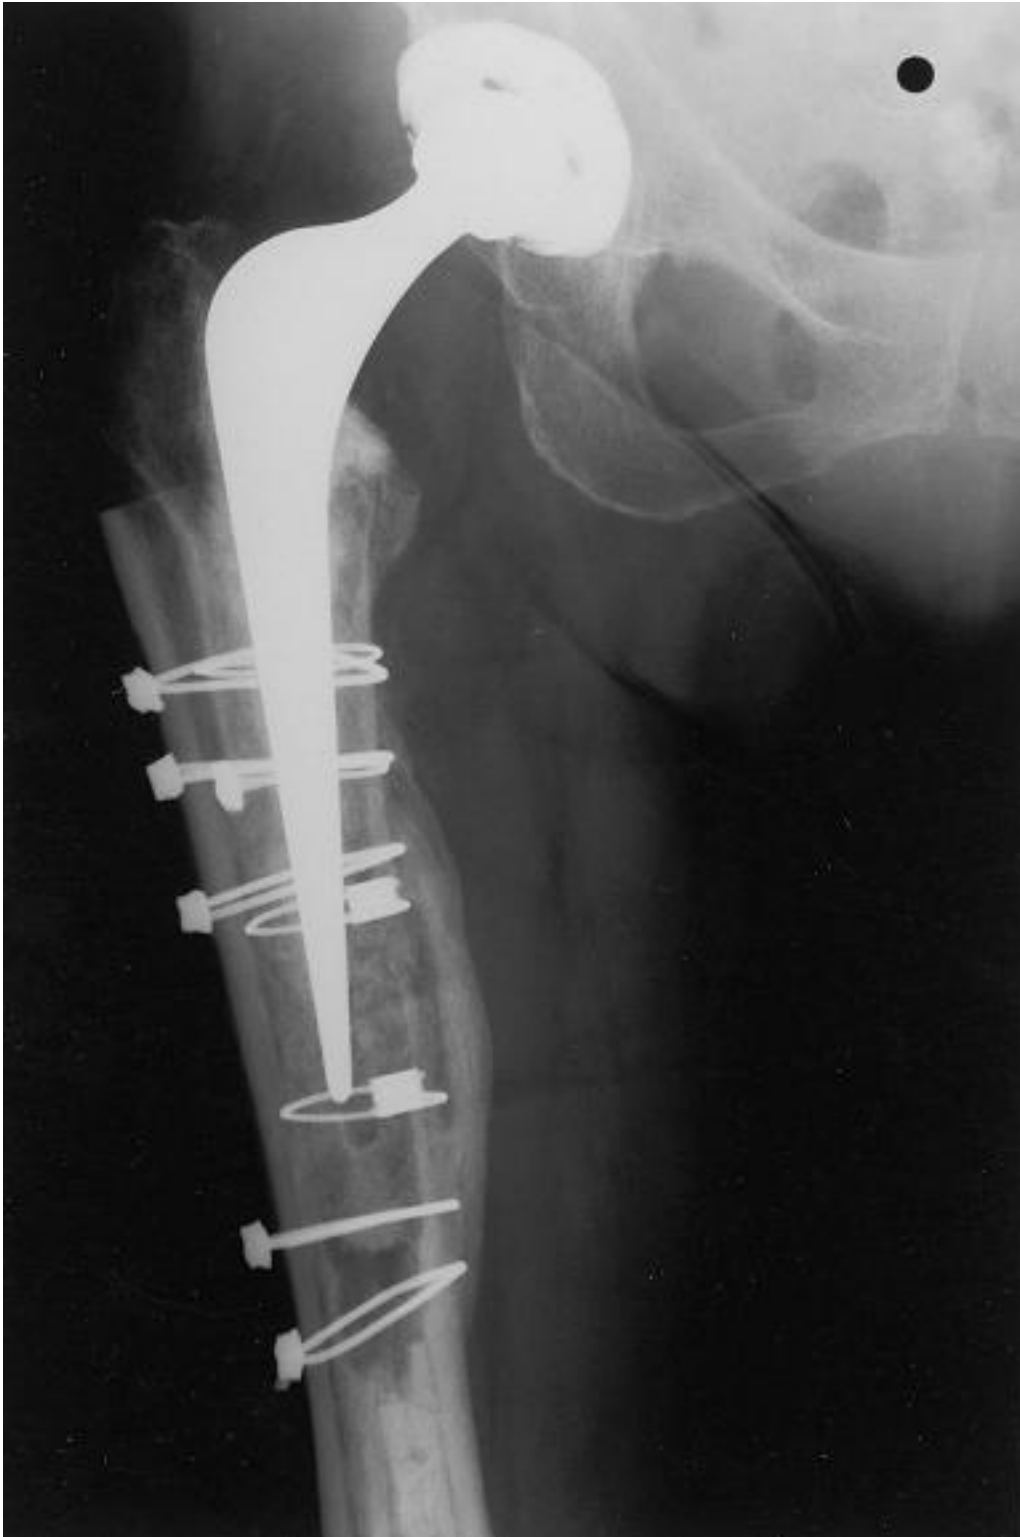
Anteroposterior radiograph of the right proximal femur taken at 28 months showing that the fracture had united in good alignment and there was good evidence of strut incorporation
